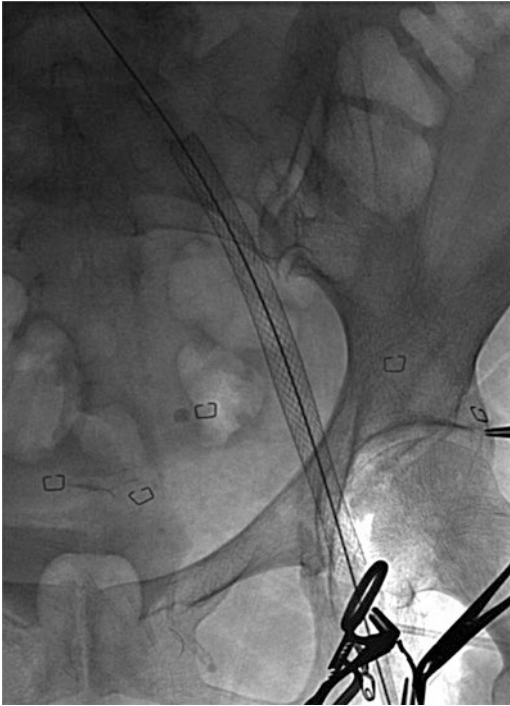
Intraoperative plain film demonstrating partially stented iliofemoral segment. The stents are constructed from the CFV to IVC
